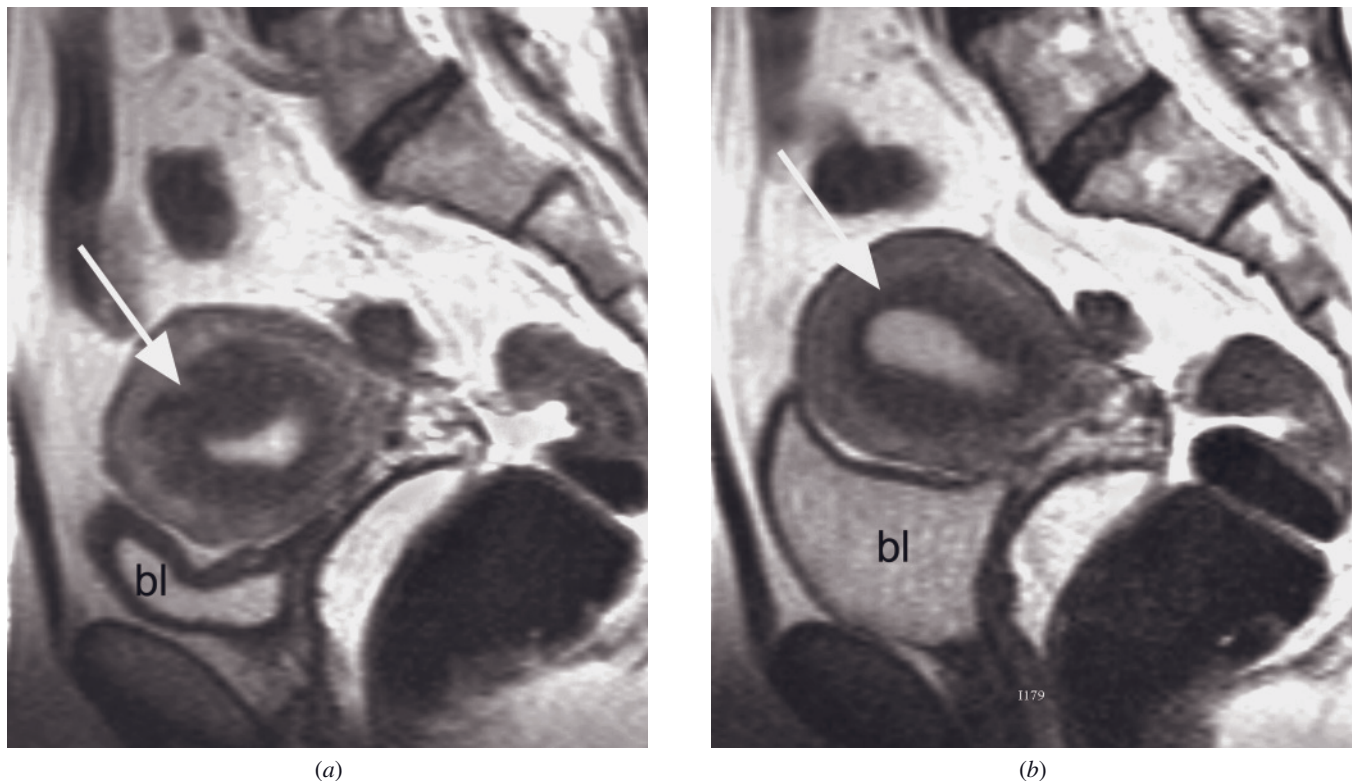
Uterine contraction. Sagittal T2-weighted ETSE images separated by 25 min. The early image (*a*) shows a focal thickening of the junctional zone with slight mass effect on endometrial canal (arrow, *a*). After 25 min (*b*), the contraction is no longer seen and the junctional zone appears normal (arrow, *b*). Also note the movement of the uterus with bladder (bl) filling during the time interval.
